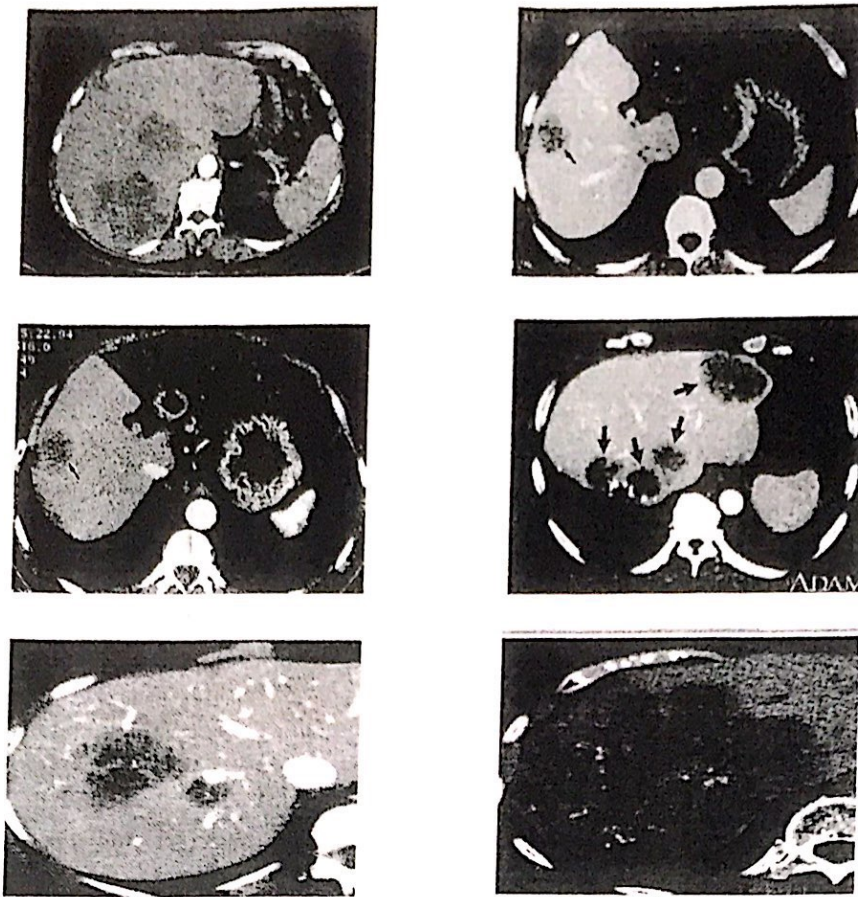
CT sample images for Hepatic Metastasis Liver.
